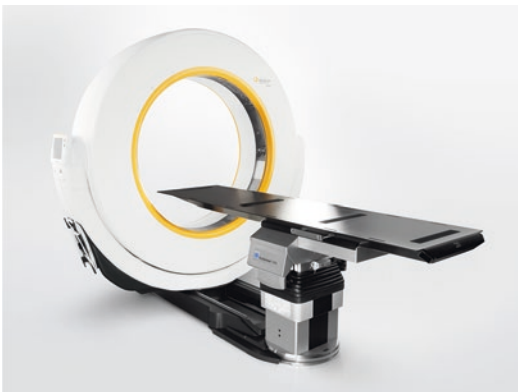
Intraoperative fan beam CT scanner (AIRO®, Brainlab) with integrated operating table. Image copyright owned by Brainlab, used with permission
